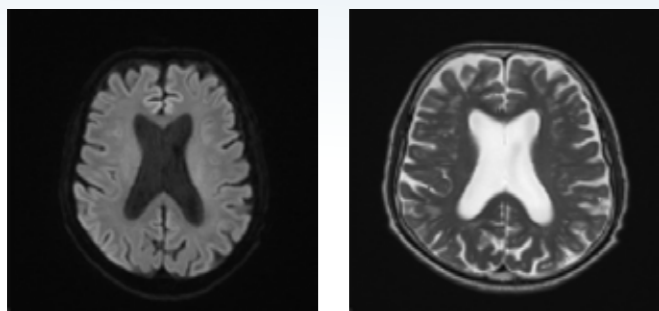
MRI after 10 days of withdrawal of therapy reveals complete resolution of the previous areas of restricted diffusion.
